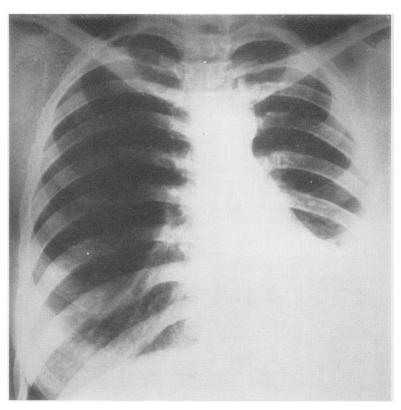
Case 3. Chest radiograph showing partially collapsed left lower lobe.
